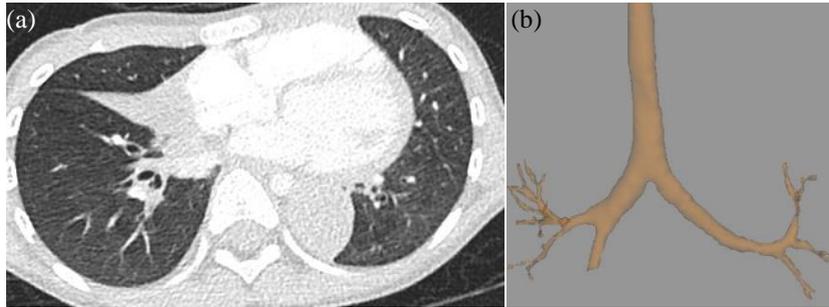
A representative case showing the failure of quantitative airway analysis in a four-year-old boy with post-infectious bronchiolitis obliterans. (a) An axial CT image shows atelectasis of right middle lobe and left lower lobe. Airways are not delineable in the affected areas. (b) Airway segmentation failed in the corresponding and distal regions.
